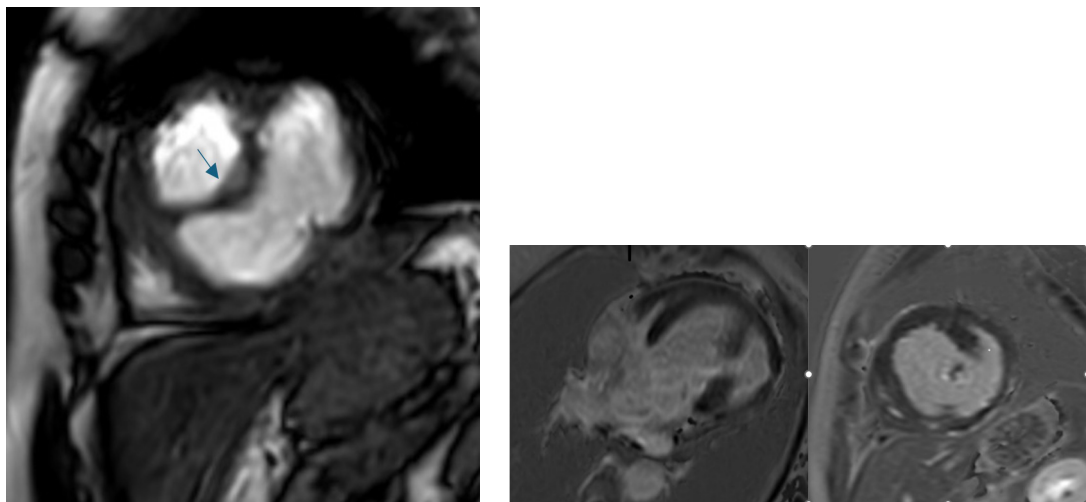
Case 2 (64-year-old female with DCM and DCLV): Cardiac MRI showing muscular ridge dividing the left ventricle into two chambers with preserved accessory chamber contractility and no fibrosis. (a) 4-chamber view showing muscular ridge (straight arrow); (b) 2-chamber view delineating the ridge; (c) Short-axis view demonstrating the muscular band; (d) Late gadolinium enhancement 4-chamber and short-axis views showing absent fibrosis.
